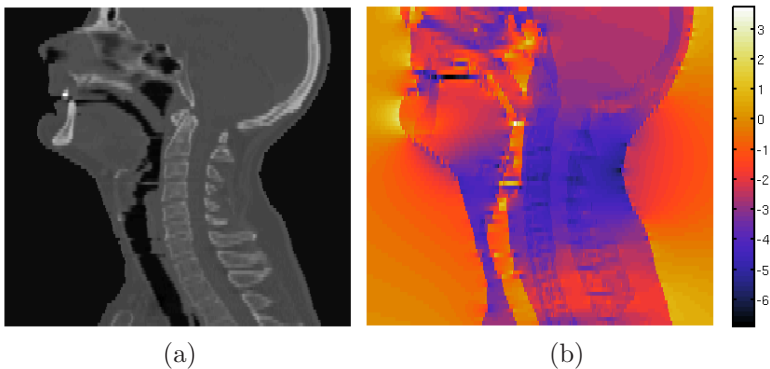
(a) CT of the head and neck area and (b) the magnetic field distribution in *ppm* of the nominal value as calculated analog to Marques and Bowtell [2005].
